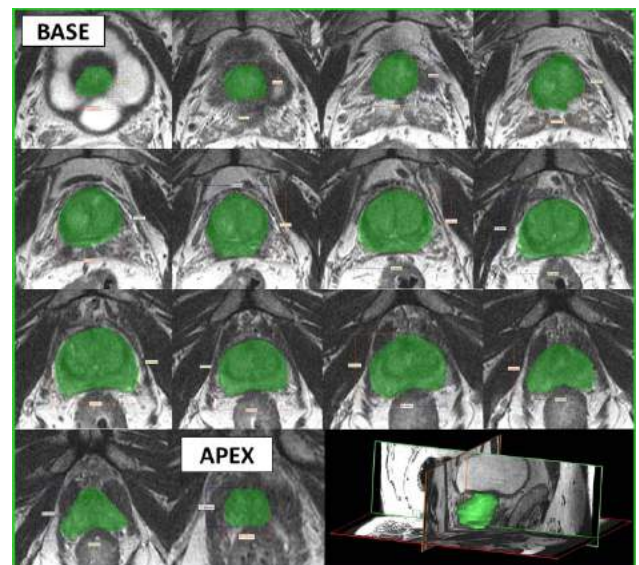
MR images obtained after chemohormonal therapy. Prior to prostatectomy, the prostate was contoured for definition of patient-specific prostate mold boundaries.
